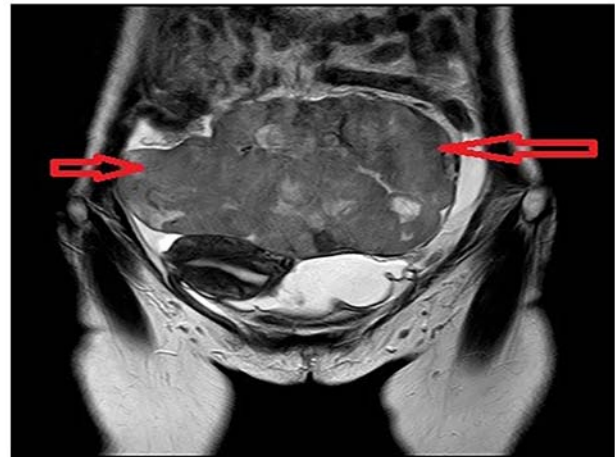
Plain MRI scan (February 2020) in which the red arrows indicate the huge pelvic mass at diagnosis before treatment, ~10x17x11.8 cm in size.
